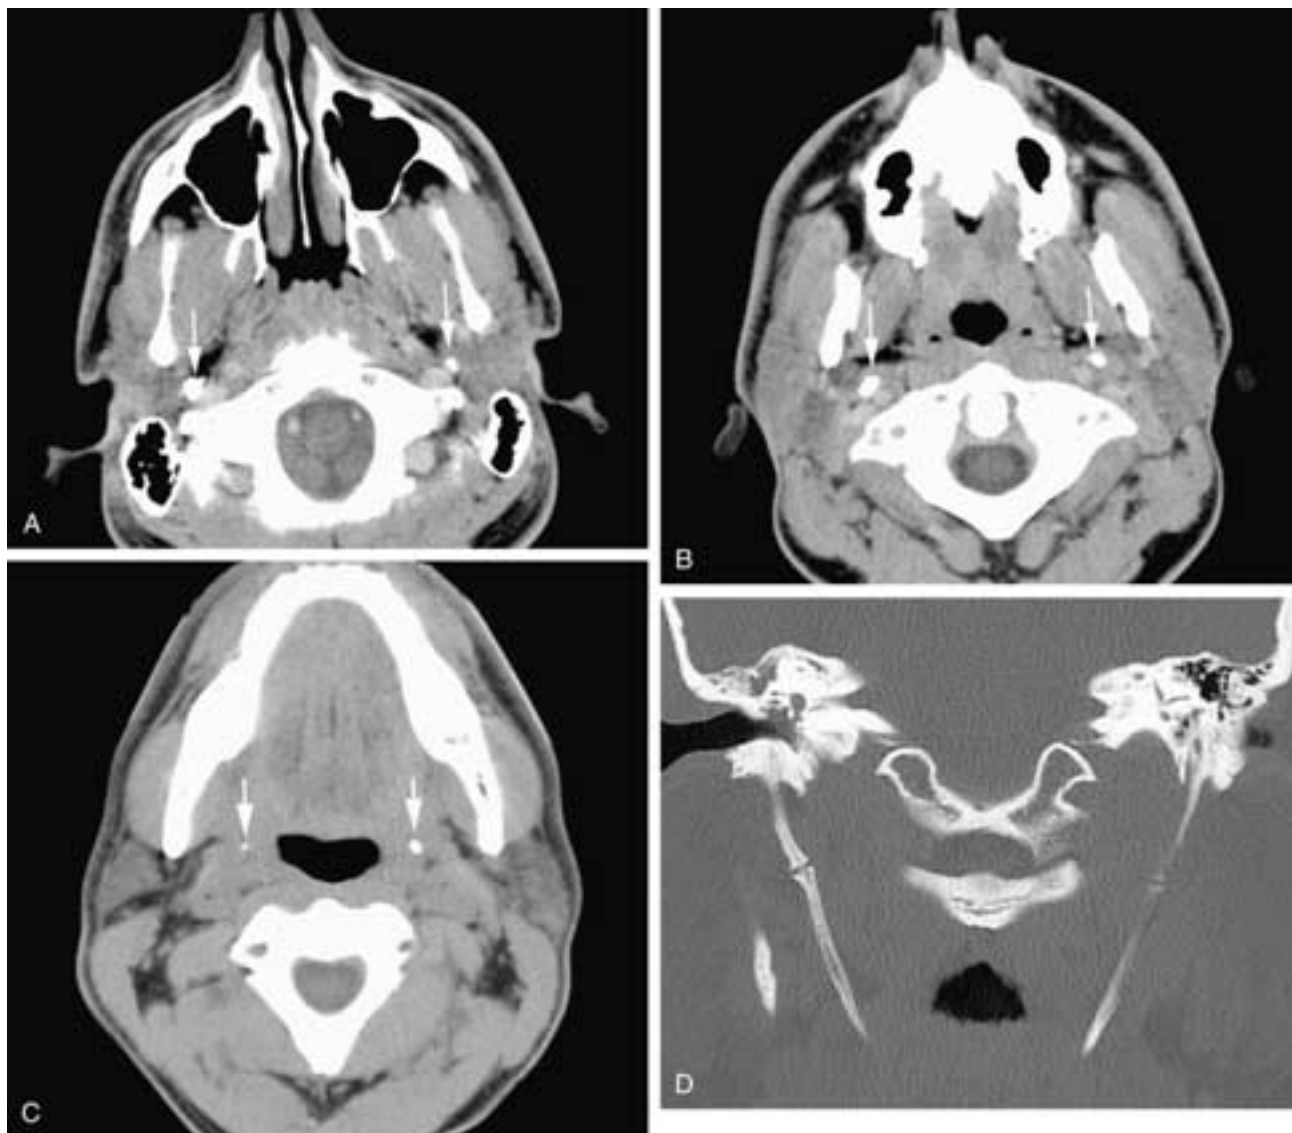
Serial cranial (A) to caudal (C) contrast-enhanced CT scans show elongation of the styloid process bilaterally (*arrows*). The normal styloid process is less than 2.5 cm. These styloid processes were 3.5 cm. This patient, who complained of pain on swallowing, had Eagle's syndrome. Coronal CT scan (D) on another patient with Eagle's syndrome shows bilaterally elongated styloid processes and ossification of the stylohyoid ligaments, virtually extending down to the hyoid bone.
